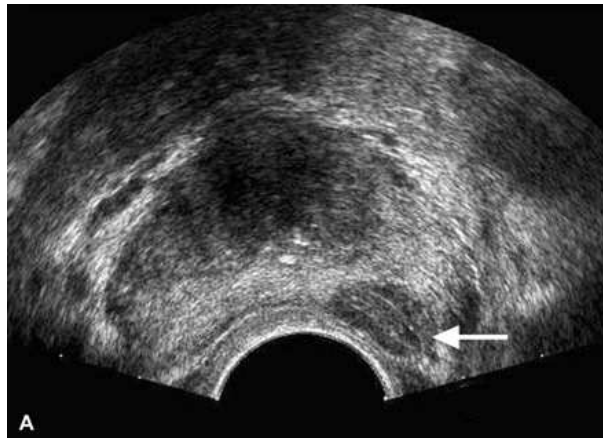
Transverse sonogram showing a hypoechoic nodule in the PZ (arrow) whose biopsy revealed a benign hyperplasia. Image courtesy Tang et al. [151]
